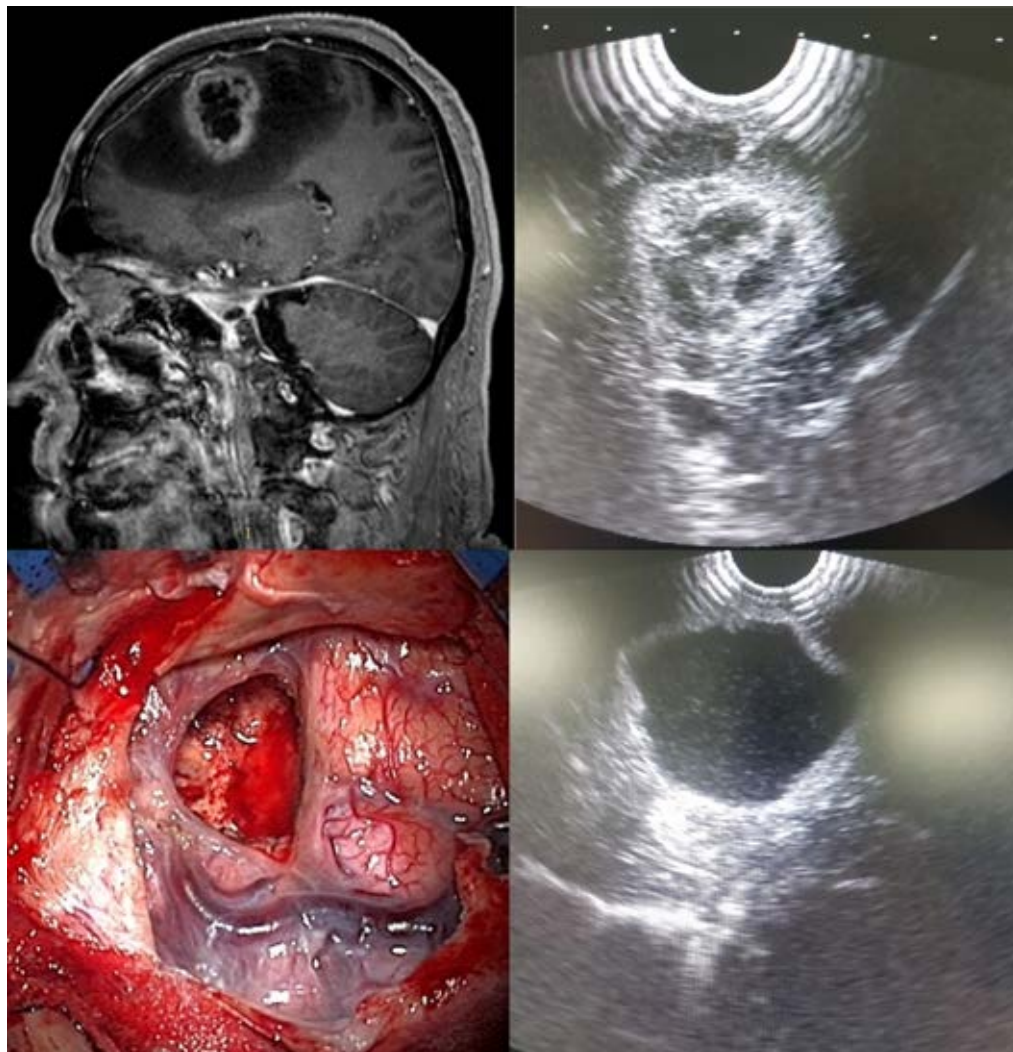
Frontal lobe glioma (Grade III): (A) preoperative MRI, (B) IOUS before resection, (C) intraoperative image, and (D) IOUS after tumor removal.
